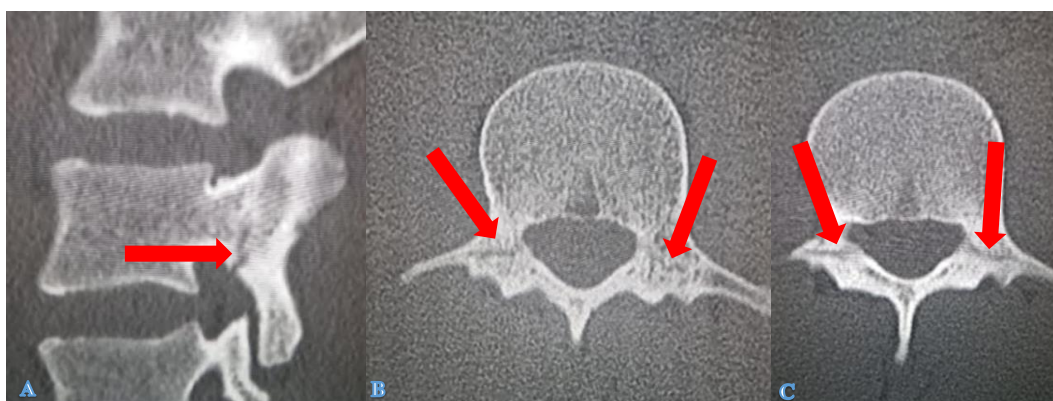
A): CT scan pedicle fracture line longitudinal course (arrow); B-C): axial CT scans with reconstruction algorithm for bone, bipedicular fracture of L3 (arrows).
